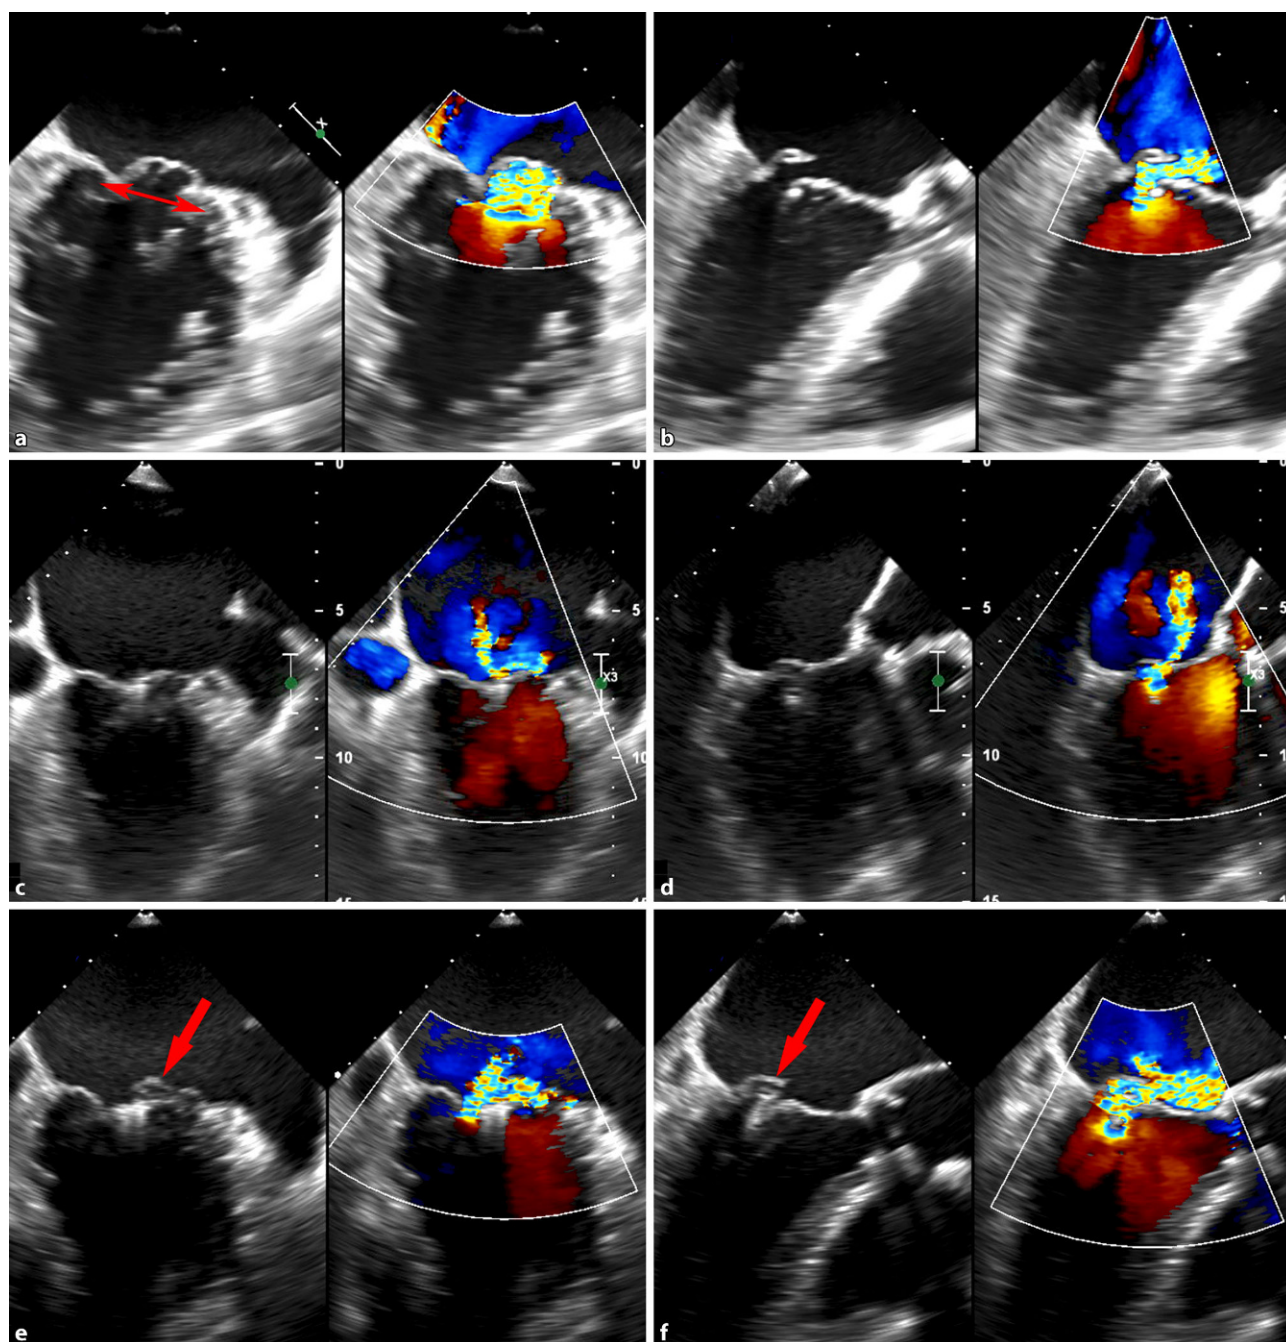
Transesophageal echocardiography in patient No. 4 with primary mitral regurgitation (myxomatous disease with a flail of the lateral scallop of the posterior leaflet [P1] and prolapse of adjacent scallops with a large coaptation width [*double arrow*]) before MitraClip implantation (a intercommissural view without and with color Doppler flow, b long axis view without and with color Doppler flow) and after implantation of two
